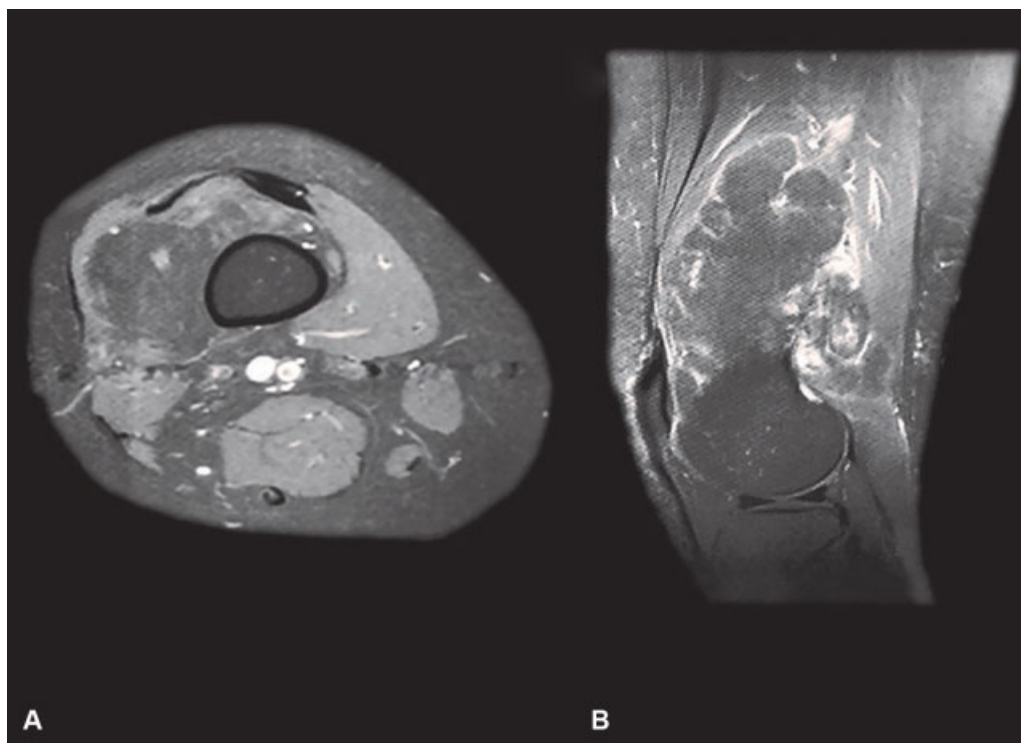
Magnetic resonance imaging of the right knee (case 2): T1-weighted axial with fat-saturation (A) and sagittal proton density fat-saturated (B) views after gadolinium contrast administration, showing a globally homogenous lobulated mass with a very irregular peripheric enhancement (but no uptake in the lesion), compatible with a lipomatous tumor.
